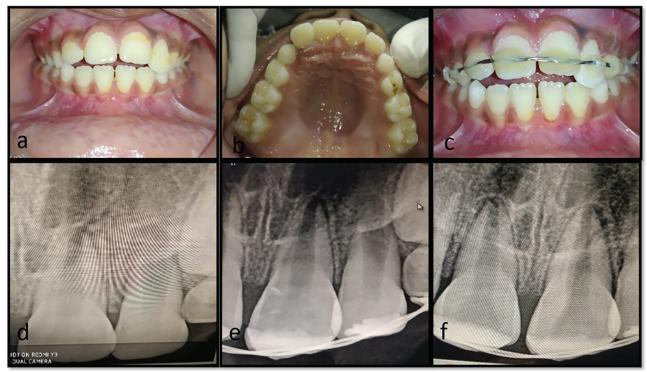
a. Pre-operative frontal view; b. Pret-operative maxillary occlusal view; c. Post-operative frontal view showing flexible splint; d. Pre-operative radiograph showing immature roots of #11 and #21; e. Immediate post-operative radiograph
